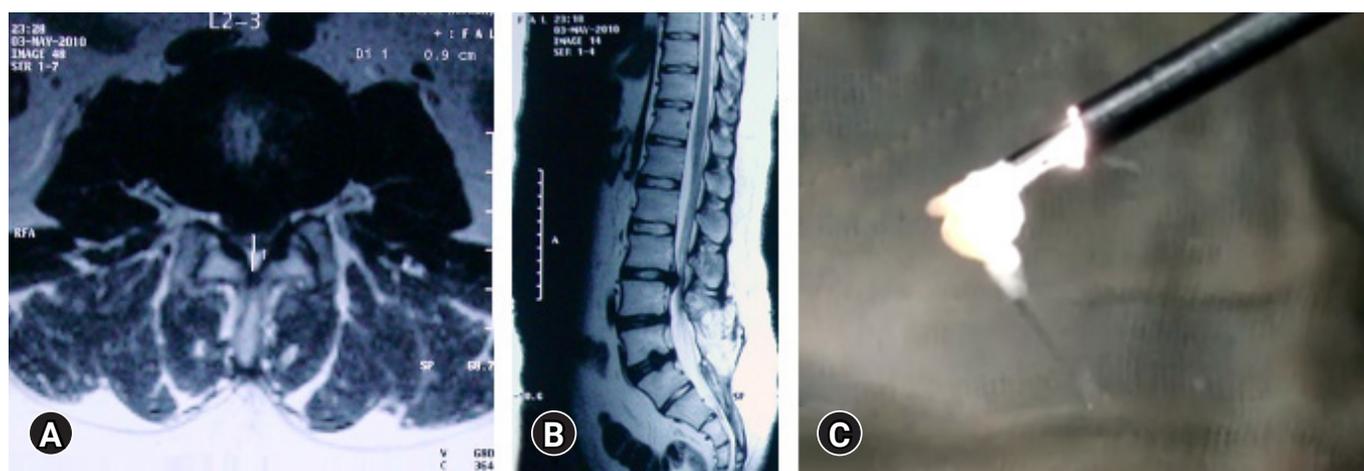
Eye balling the size of fragment and comparing with the MRI. Previous two level operated Open surgery patient with a new L2-3-disc herniation (A, B), with a matched fragment en-masse removal (C).
